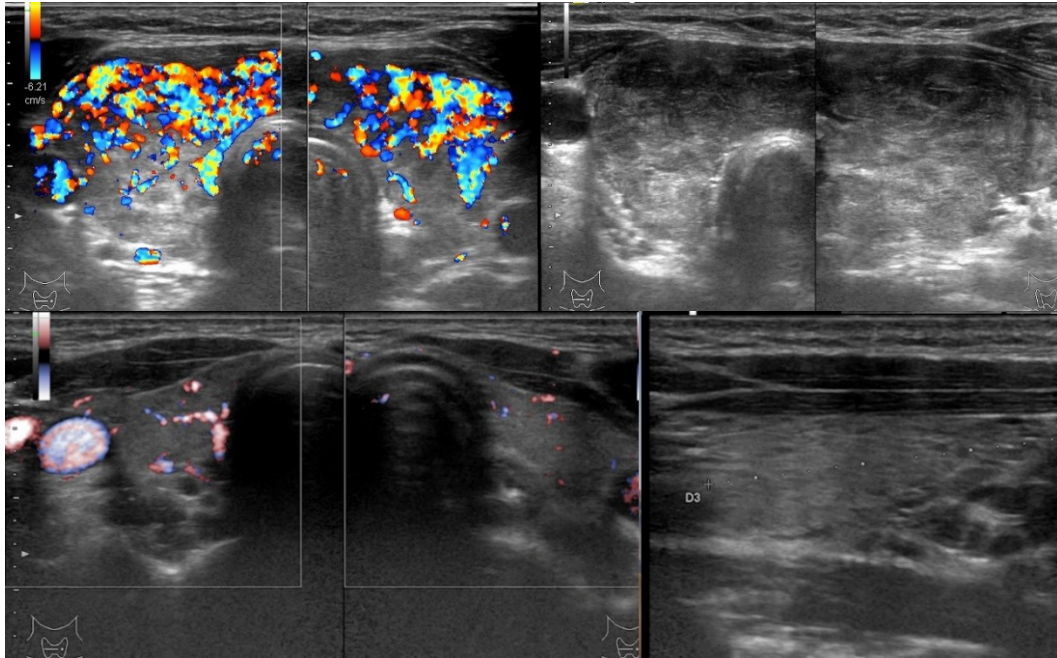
Thyroid B-mode ultrasound (upper right) showing increased thyroid volume (40 ml) and thyroid inferno in Color Doppler (upper left) – active Graves' Disease; and normalized volume (15 ml) B-mode longitudinal view (lower right) and normal vascular pattern (lower left) – inactive Graves' disease.
